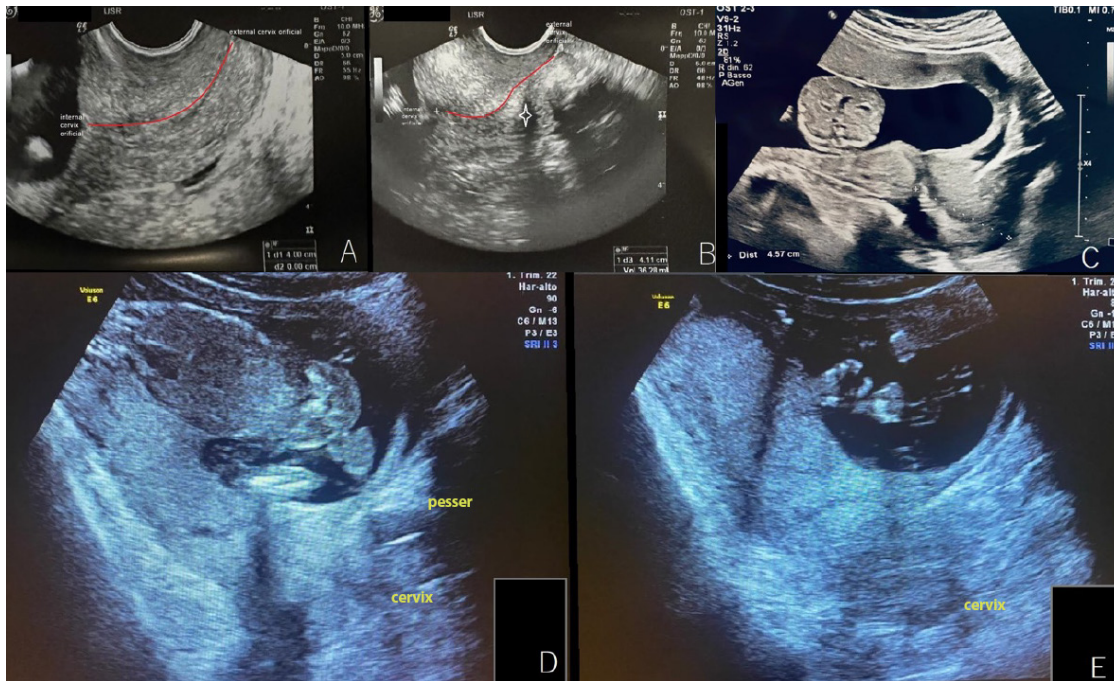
Case 1: (A) Under the pubic region and cervix of the patient, at first hospital attendance; (B) Modified angle of cervix after pessary placement. The acoustic shadow of the pessary is highlighted with a white star while the direction of the cervix is indicated with a red line; (C) Ultrasound visualization of the retroposed cervix at 16-week follow-up. Case 2: (D) Ultrasound visualization of Arabin pessary at routine follow-up visit; (E) A persistent retroposed cervix after pessary removal
